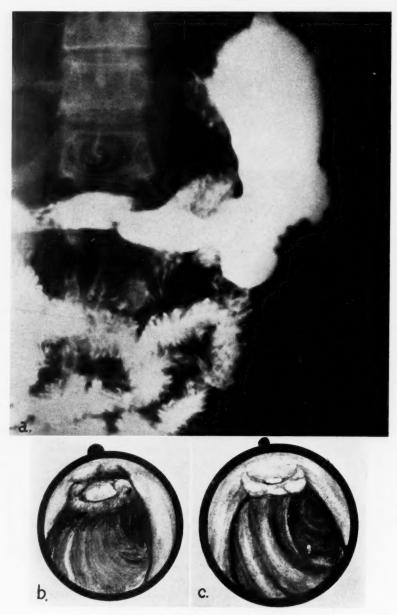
a. Normal roentgenogram.
